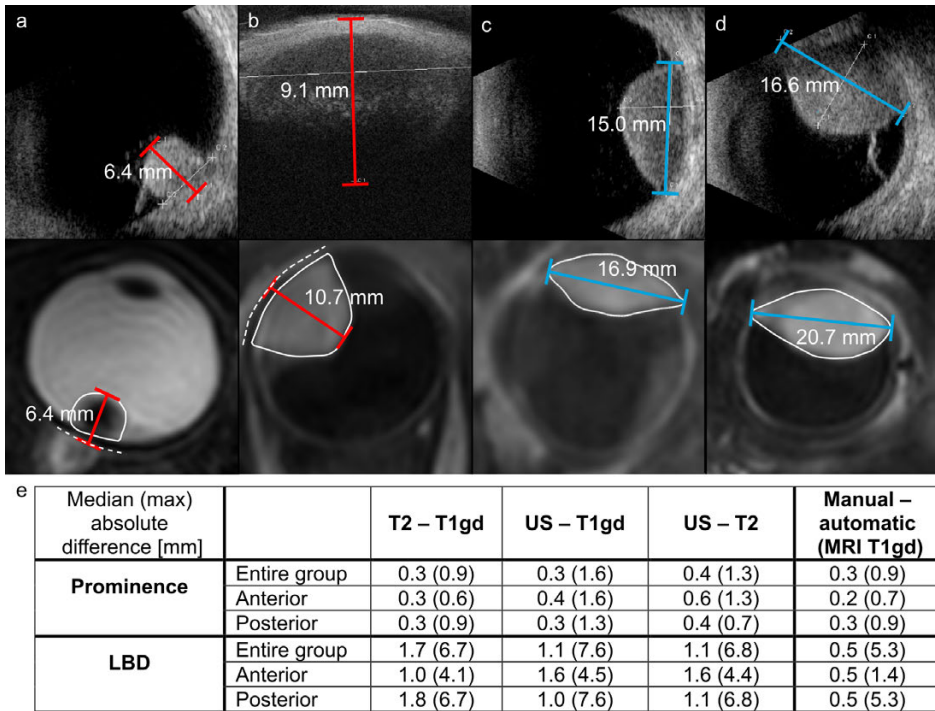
Four typical examples of ultrasound (upper images) and MRI measurements (lower images) from four different patients and an overview of the main comparisons. (a) T2 and ultrasound measurements were similar. (b) T1gd prominence was larger for an anteriorly located tumour for which the extent was not entirely visible on UBM. (c) T1gd LBD was larger than on ultrasound for a tumour whose extent was visible on both modalities. (d) T1gd LBD was larger than on ultrasound and extent was not entirely visible on ultrasound. (e) Overview of the main comparisons performed in this study: automatic T2 - automatic T1gd, ultrasound (US) - automatic T1gd, ultrasound - automatic T2, manual T1gd - automatic T1gd.
